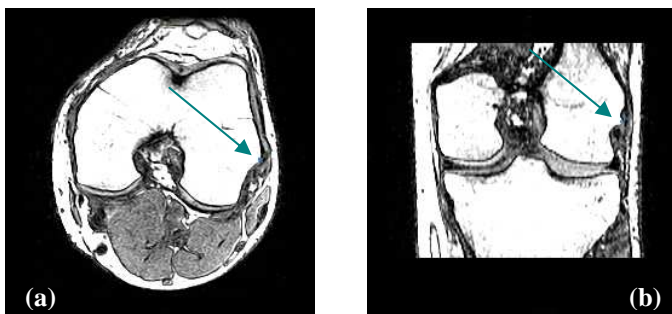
Three-dimensional transverse (a) and coronal (b) plane MR images showing the segmented medial femoral epicondyle.
